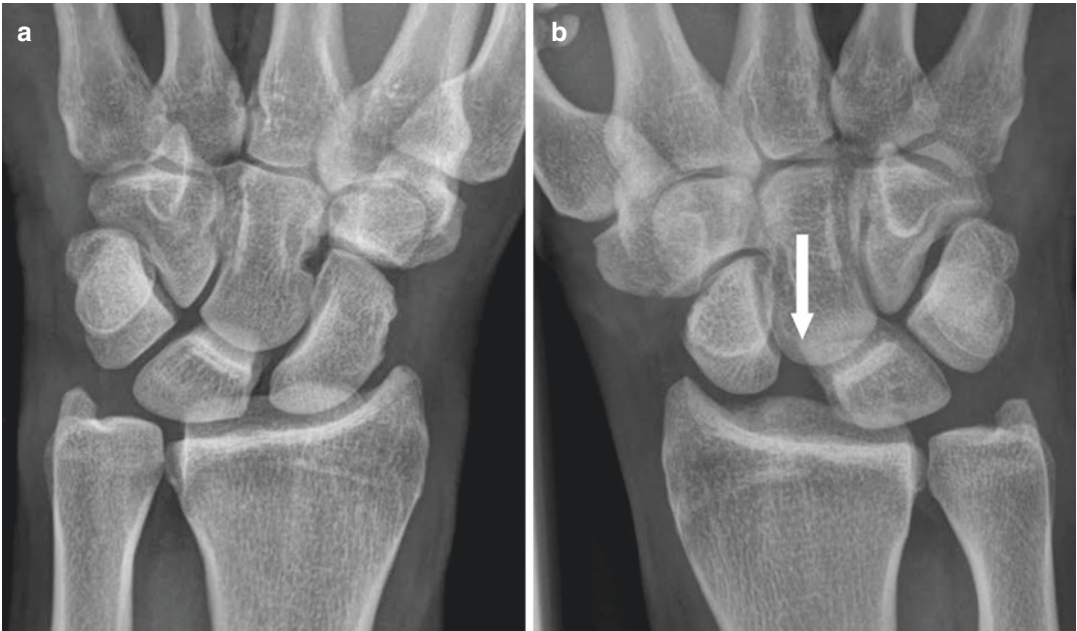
Anteroposterior radiographs of a left (a) and right (b) wrist of the same athlete. The radiographs were taken asking the patient to close his hands tight. As pointed by the arrow
